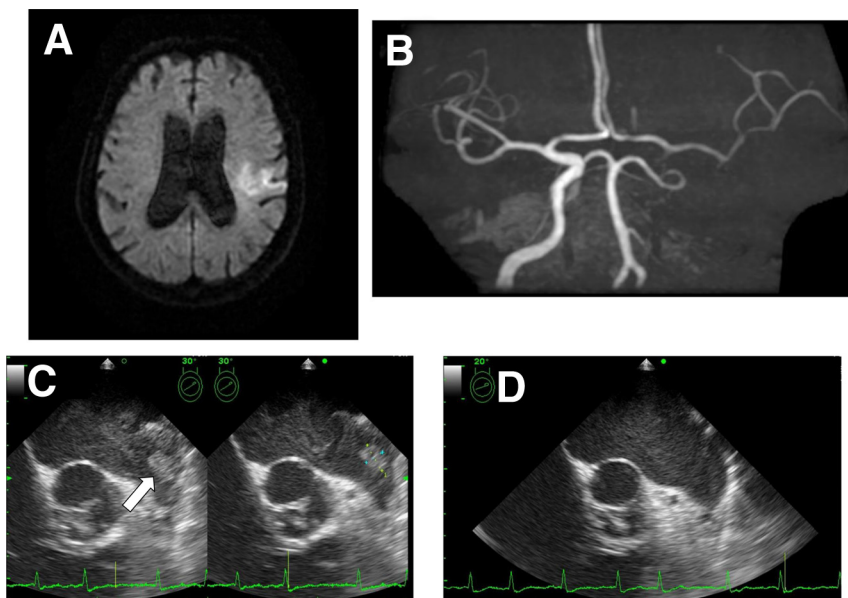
(A) Axial diffusion-weighted magnetic resonance image at admission showing hyperintense signal in the left temporal cerebral cortex. (B) Magnetic resonance angiography at admission showing chronic occlusion of the left internal carotid artery and the left middle cerebral artery through the cerebral arterial circle of Willis. (C) A mobile thrombus (arrow, 13.3 \times 8.7 mm) in the left atrial appendage and a remarkable smoke-like echo in the left atrium detected on TEE performed on day 8. (D) Disappeared thrombus and reduced smoke-like echo on TEE performed on day 40 after rivaroxaban therapy. Abbreviation: TEE, transesophageal echocardiography.
